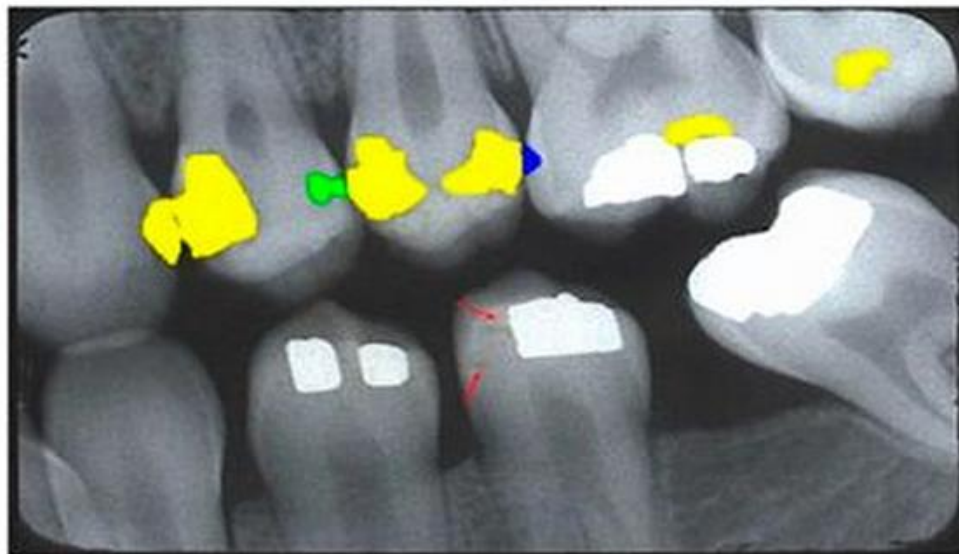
Bitewing radiograph with AI-assisted caries segmentation. Blue = moderate Interproximal Caries (IPC), not reaching the dentin-enamel junction (DEJ); Green = advanced IPC reaching or passing the DEJ into dentin; Yellow = severe IPC extending more than halfway toward the pulp; Red arrows = radiolucent processing artifacts. Source: Iannucci J. Radiographic Caries Identification (RCI). The Ohio State University College of Dentistry. Reprinted with permission [20].
